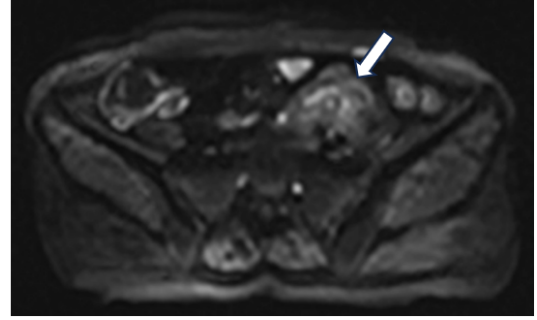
Diffusion weighted imaging, DWI.
